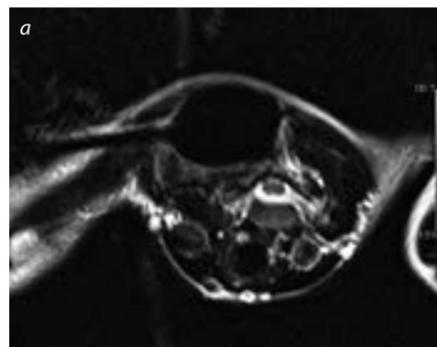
Voluminous cervico-thoracic DT treated with percutaneous cryoablation in two consecutive sessions. (a) The superior part of the lesion was treated with percutaneous cryoablation under MR guidance and the inferior 6 months later under CT guidance (b). (c) The MR control before and after treatment demonstrates the complete resolution of the lesion. (d) Significant reduction of the tumour size was noted 6 and 12 months post-treatment. The patient was symptom-free at short- and long-term follow-up.
